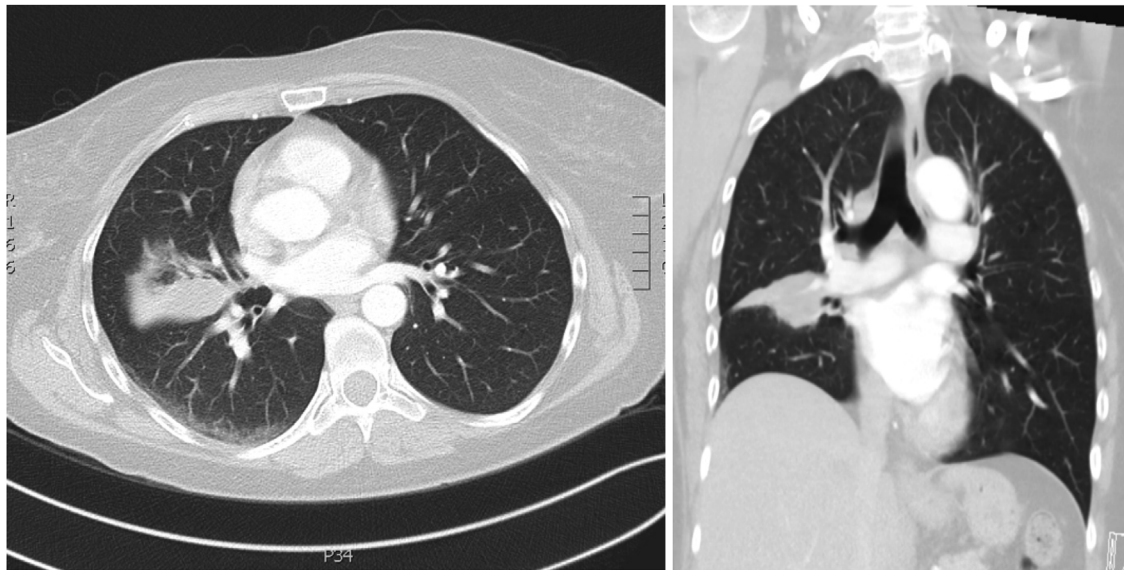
CT tomography of chest in axial and coronal view shows middle lobe consolidation of the Right lung, suggestive of cryptococcoma.
